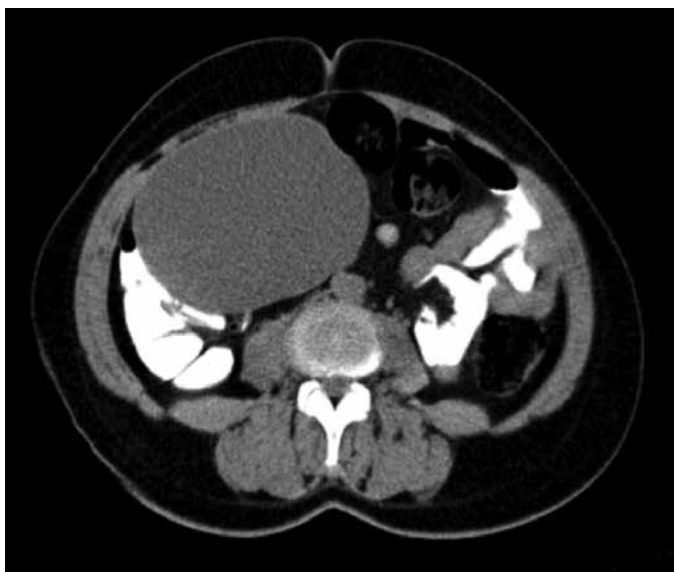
Axial CT images before IV contrast demonstrate the homogeneous giant cystic mass which take origin from the right adnexa
